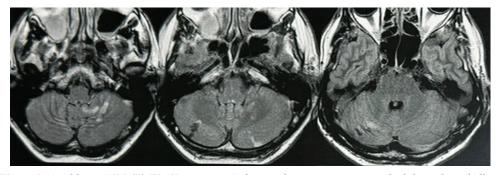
Axial brain MRI (T2 FLAIR sequences) showing hypointense areas in the bilateral cerebellar hemispheres with loss of cortico-subcortical differentiation, consistent with subacute ischemic lesions. There is symmetric involvement of the posterior cerebellar lobes, with no significant mass effect or midline shift. Findings are compatible with bilateral cerebellar infarctions, possibly related to vertebral artery dissection or paradoxical embolism via PFO.
